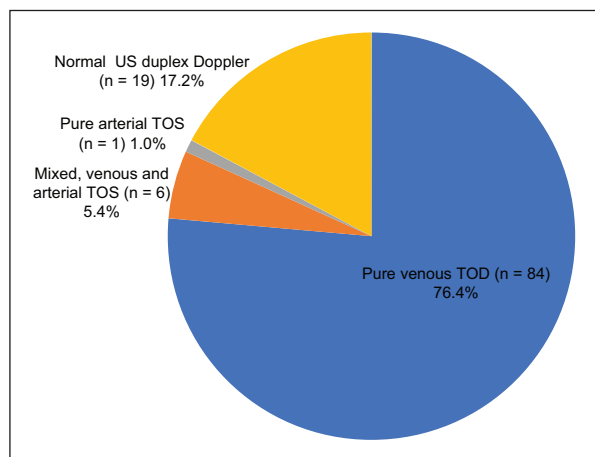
Normal and abnormal US duplex Doppler in patients with clinical suspicion of a vascular TOS. The diagnosis of venous (pure or mixed) and arterial TOS was defined based on ultrasound findings.
